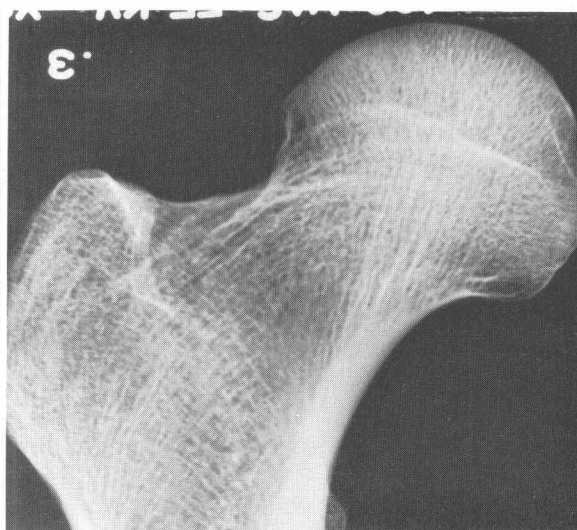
(Continued) *D.* Radiograph of same femur taken at 72-inch focal-film distance with an object-film distance of 48 inches and a target size of 1.3 mm. Note the marked blurring that results. *E.* Here the same factors were employed as in *D*, except that the focal spot size was 0.6 mm. Reasonably good definition of the trabecular pattern of the femur results, even though the object-to-film distance was 48 inches as before. *F.* The focal spot size here is 0.3 mm., with all other factors the same. This is the optimum target size for detail when such long object-to-film distances are necessary. The magnification in *D*, *E*, and *F* is approximately times 3.
